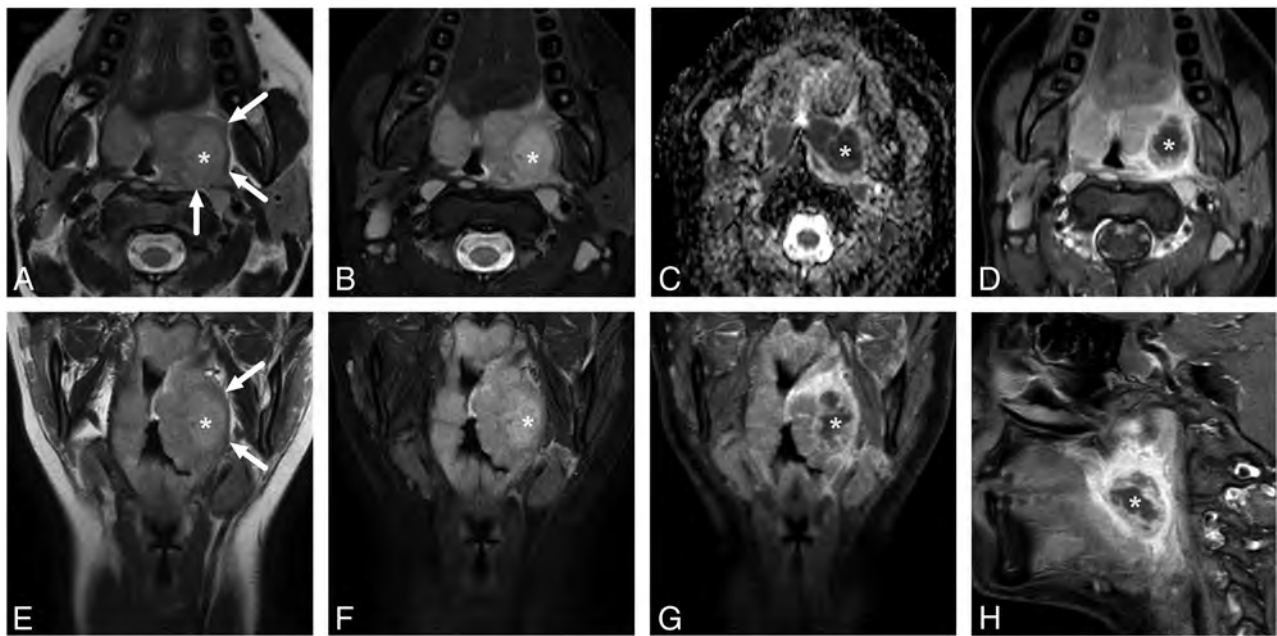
Uncomplicated PTA in an 18-year-old male patient with a sore throat. In-phase axial (A) and coronal (E) as well as fat-suppressed axial (B) and coronal (F) T2-weighted Dixon images reveal a slightly T2-hyperintense abscess (asterisk) lateral to the left palatine tonsil. The edematous pharyngeal constrictor muscle can be seen around the palatine tonsil (arrows in in-phase images A and E). The abscess shows restricted diffusion on the ADC map (C) and a nonenhancing core surrounded by an enhancing rim in axial (D), coronal (G), and sagittal (H) post-Gd fat-suppressed T1-weighted Dixon images.
